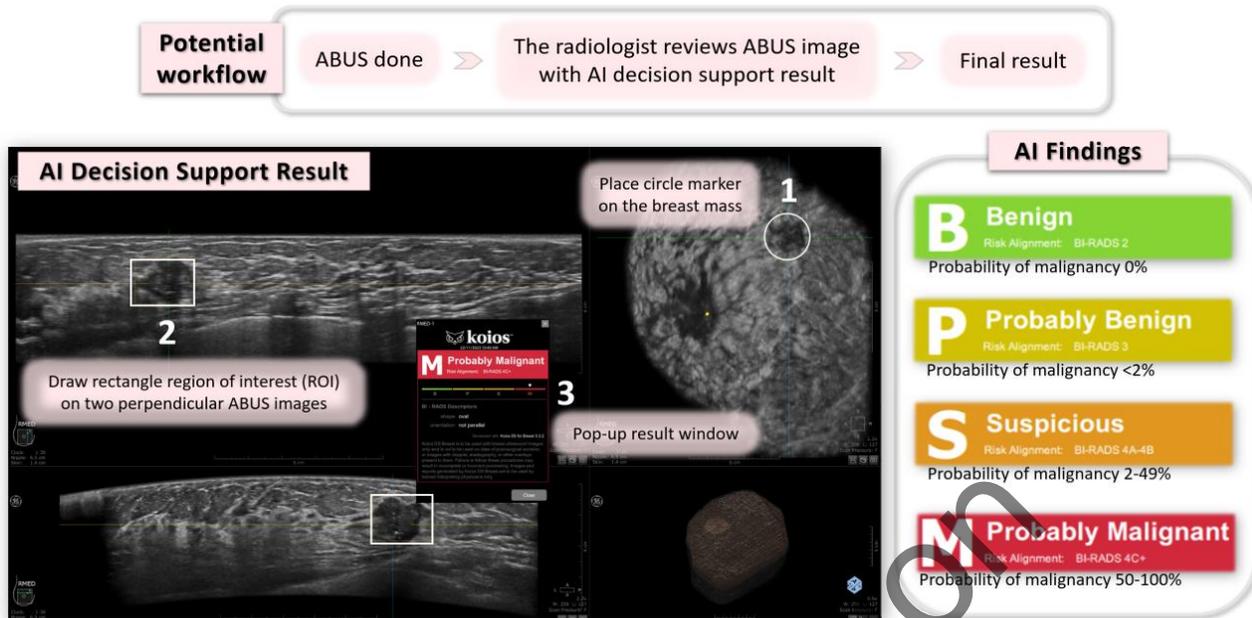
Workflow of AI-assisted decision support for lesion assessment in ABUS. ABUS, automated breast ultrasound; AI, artificial intelligence.
